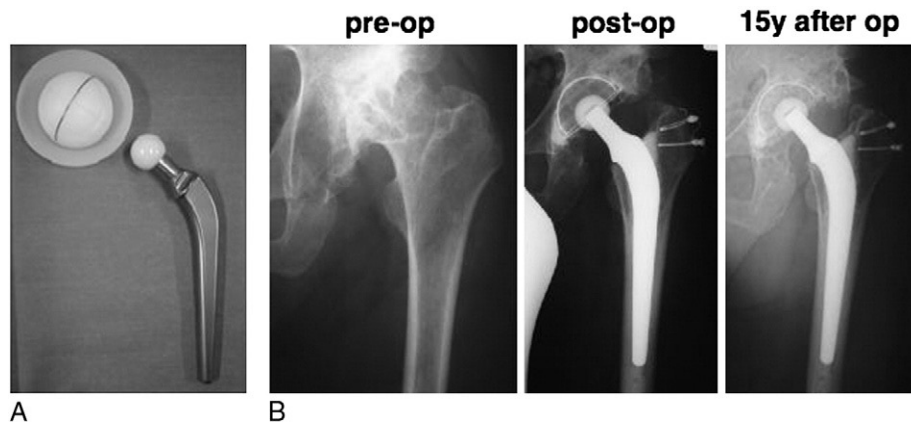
(A) Photograph showing a PHS KC prosthesis and a 22-mm alumina ceramic head. (B) Radiographs taken preoperatively, postoperatively, and at 15 years after surgery.
